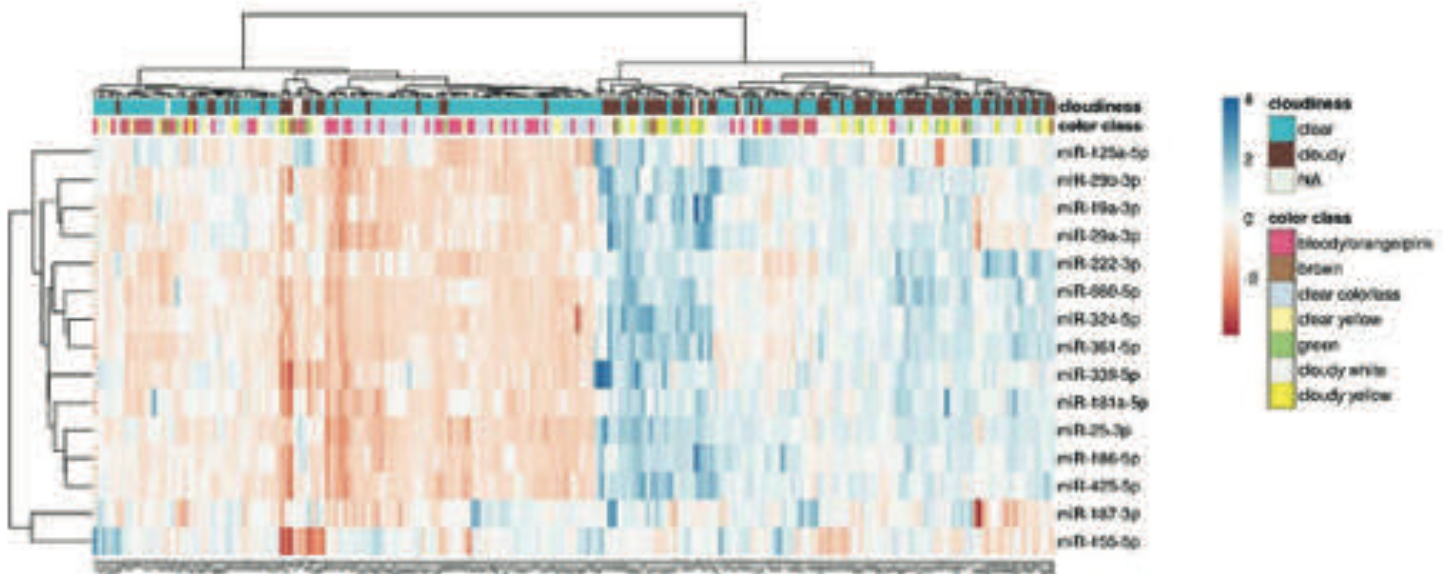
Unsupervised hierarchical clustering of 211 nipple aspirate fluid samples based on the expression pattern (delta delta CT) of 15 miRNAs. Rows are centered and unit variance scaling is applied to rows. Imputation was used for missing value estimation. Both rows and columns are clustered using Euclidean distance and Ward linkage.
